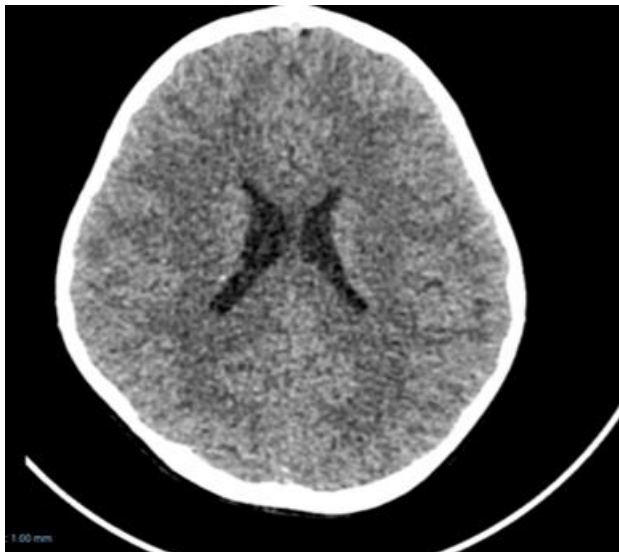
CT brain scan is unremarkable
